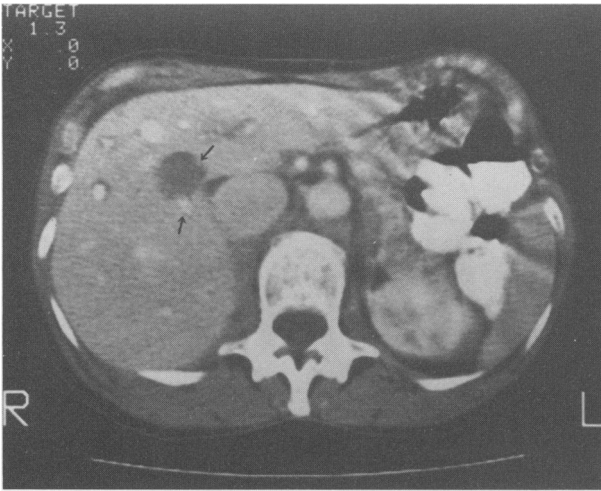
A CT section of the upper abdomen during the immediate vascular phase of contrast enhancement (angiogram) shows the lesion is of low attenuation with small marginal contrast areas (arrows).
